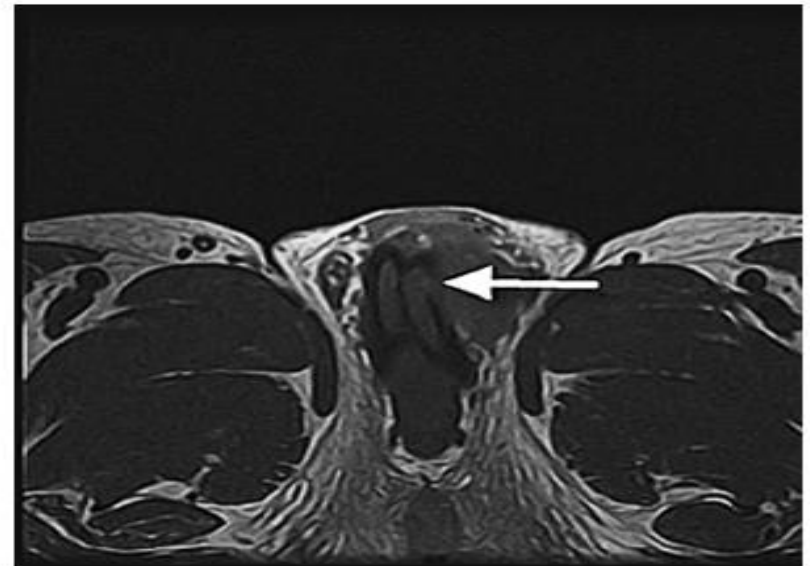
Axial T1-weighted MRI of penis showing left subcutaneous hematoma of intermediate signal intensity and adherent to the adjacent corpus cavernosum with a defect at the adjacent tunica albuginea (arrow).
